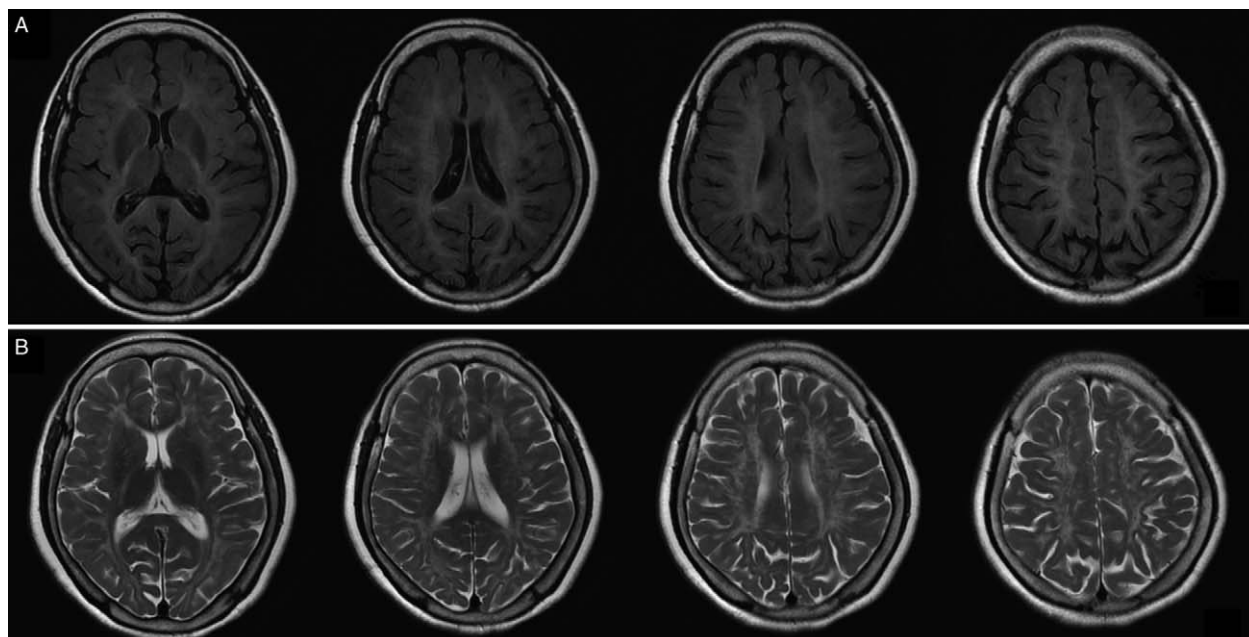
Diffuse white matter hypomyelinations in bilateral cerebral hemispheres. Axial FLAIR images (A); Axial T2WI images (B). FLAIR: Fluid attenuated inversion recovery.
